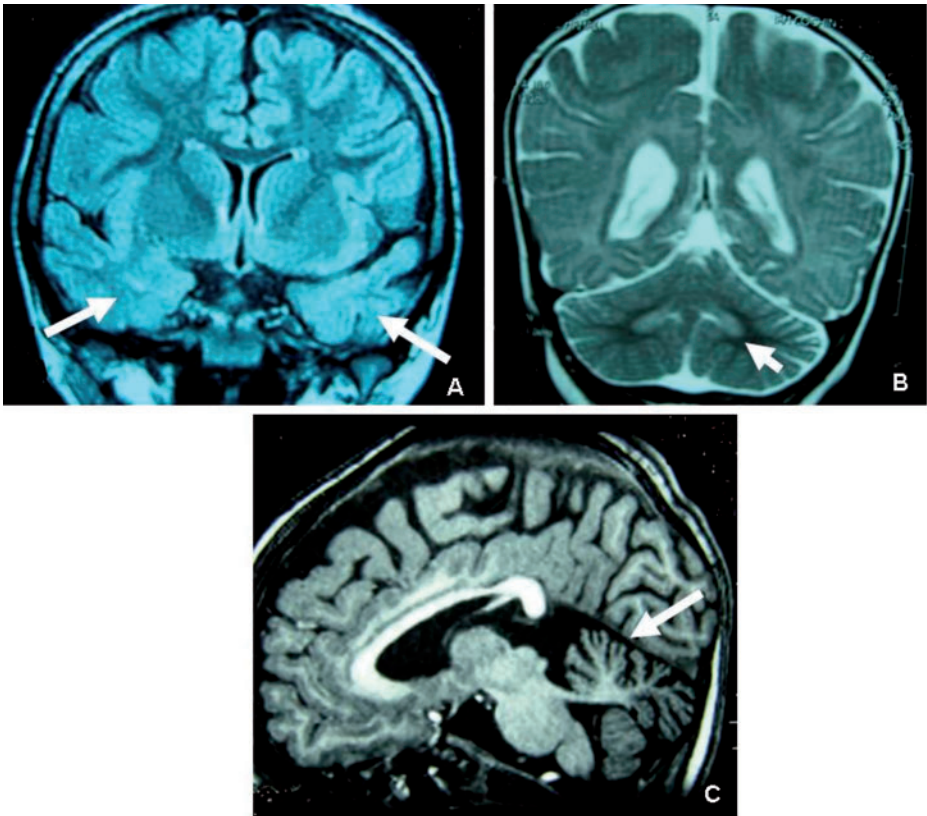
Brain MRI findings for patients with *CDKL5* mutations. Abnormalities consistently noticed include (A) marked white matter hyperintensities in the temporal poles (T2 FLAIR sequence), (B) moderated hyperintensities of the dentate nuclei (T2 FLAIR), (C) cerebellar atrophy (T₁-weighted sagittal images). Arrowheads show the location of the main abnormalities in each figure.
